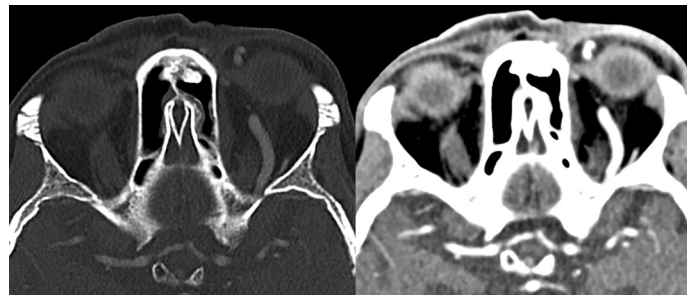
Enhanced and non-enhanced CT-Scan demonstrated abnormal supraorbital artery.
